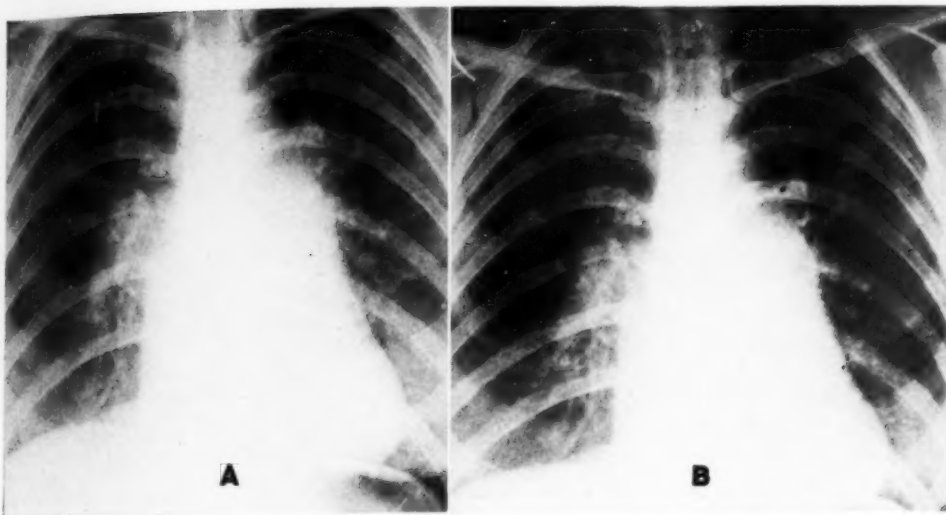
Severe mitral disease. A. Roentgenogram with normal pressure. B. Roentgenogram with pressure of 80 cm. of water.
